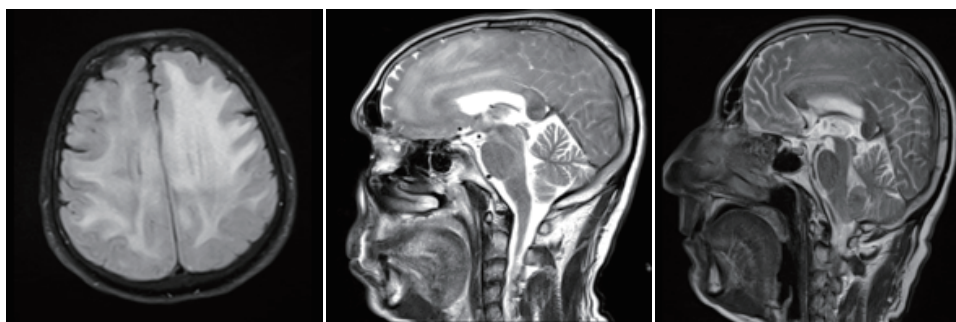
The lesion diffusing from the corpus callosum to the opposite hemisphere with a significant increase in the control brain MRI images taken after the clinical worsening of case one when compared to the initial brain MRI images
